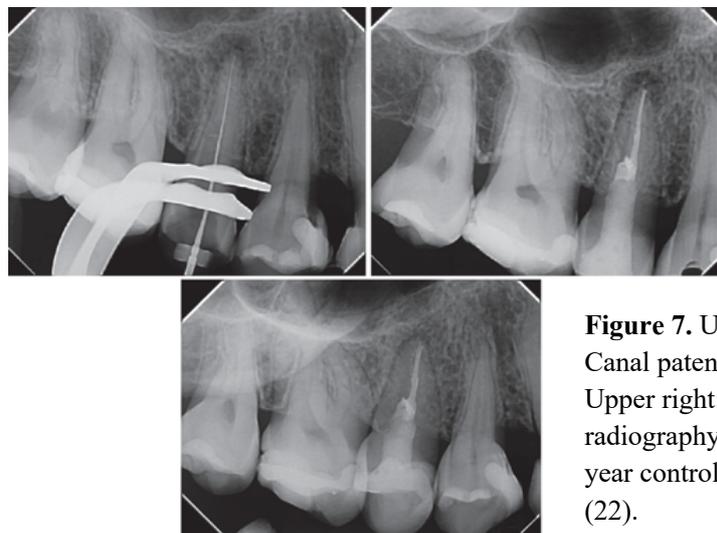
Upper left: Canal patency checking. Upper right: final radiography. Lower: One-year control radiography (22).
